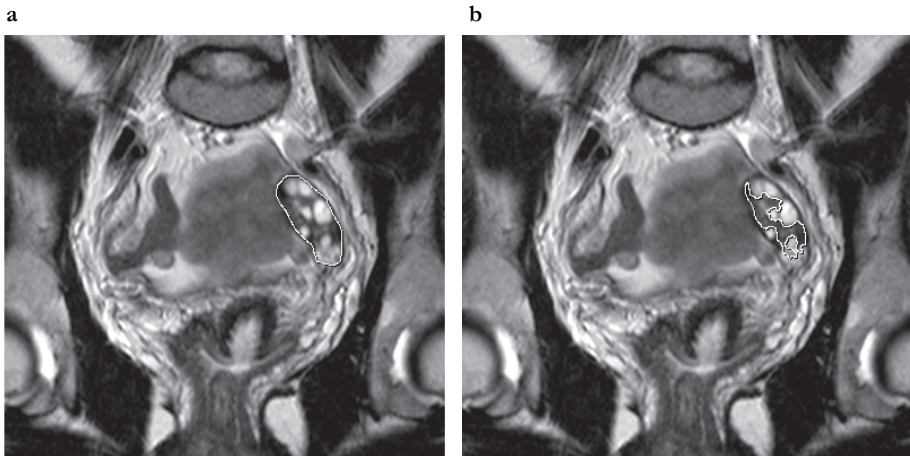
T2-weighted TSE scans in the coronal plane. In (a), the outer border in the largest plane section of the left ovary is manually outlined to measure the total cross-sectional area A . In (b), the stroma S is outlined in the same maximal section. The areas are then calculated automatically by the workstation's software, and the S/A ratio can subsequently be calculated.
